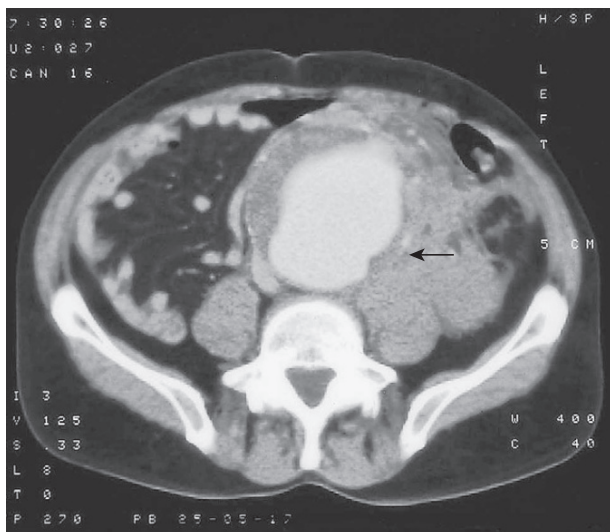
CT scan of the abdomen showing a large leaking abdominal aortic aneurysm. Note the areas of calcification in the wall of the aneurysm. There is evidence of leakage to the left of the aneurysm (arrow).
